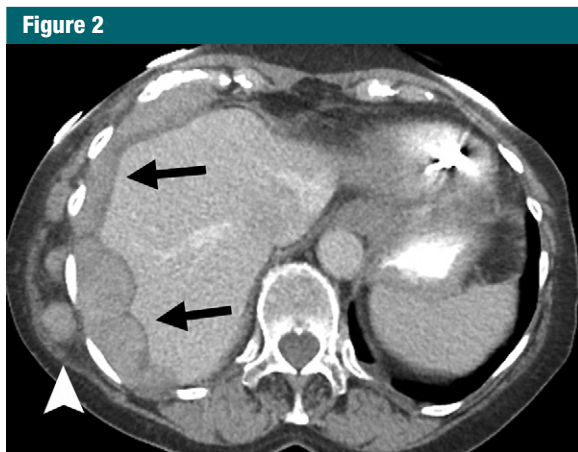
Axial contrast material-enhanced CT scan in a 75-year-old patient with papillary serous adenocarcinoma and extensive perihepatic scalloping without invasion (arrows). The patient also had right-sided chest wall disease (arrowhead).
